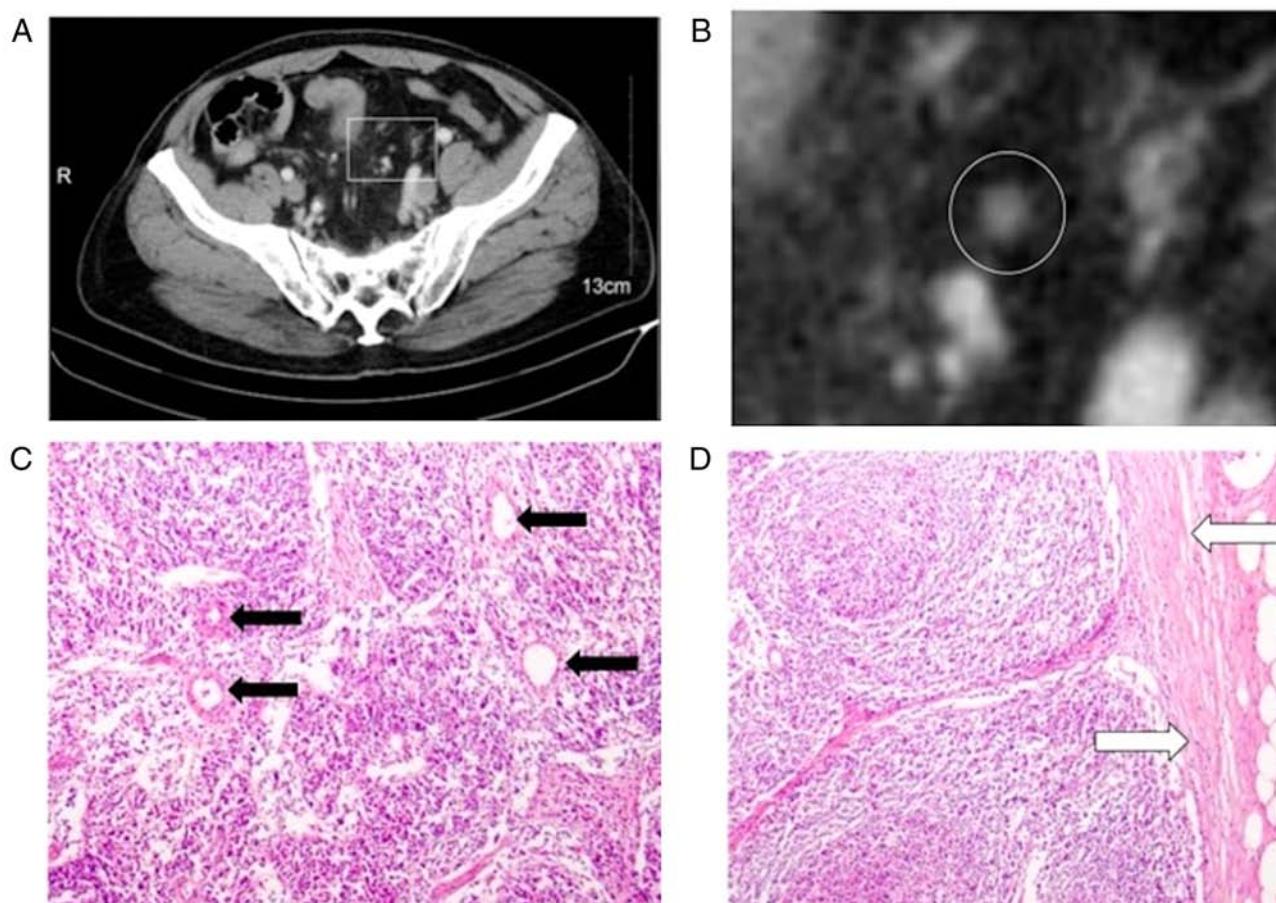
(A) Contrast-enhanced, equilibrium phase CT scan images of a lymph node with colon cancer of the rectum. (B) A lymph node exhibiting core enhancement features. (C) The black arrow indicates a small blood vessel in the central region of the lymph node. (D) The white arrow indicates the capsule of the lymph node and blood vessels in this region were rare.
